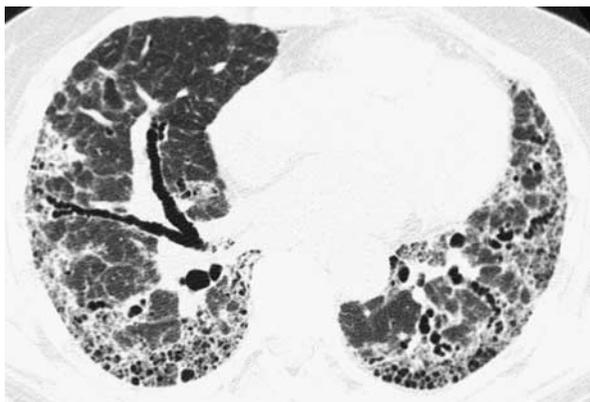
UIP pattern in HP. Axial HRCT image through the lung bases shows honeycombing, reticulation, and traction bronchiectasis with a subpleural predominance. This would be considered “definite UIP” and is indistinguishable from IPF.
